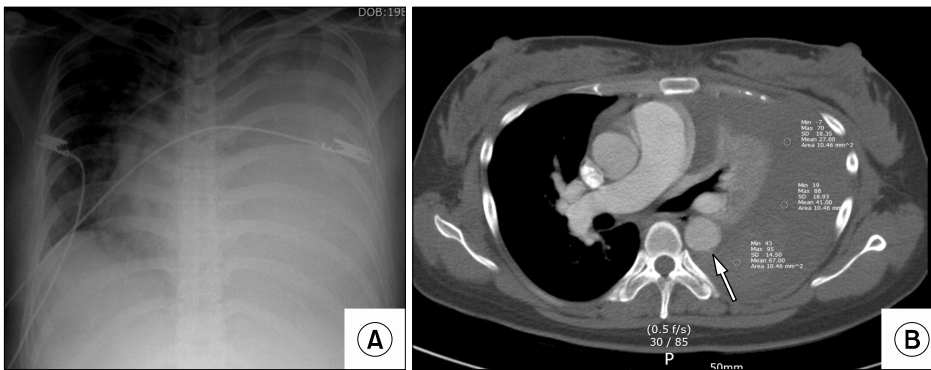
(A) A simple chest X-ray showed a large left pleural effusion with total atelectasis of the left lung. (B) Chest computed tomography showed a large hemothorax with total atelectasis of the left lung. The red arrow shows the minimally sized defect of the aortic wall. The pleural fluid near the defect displayed higher Hounsfield units than the fluid far from the defect.
